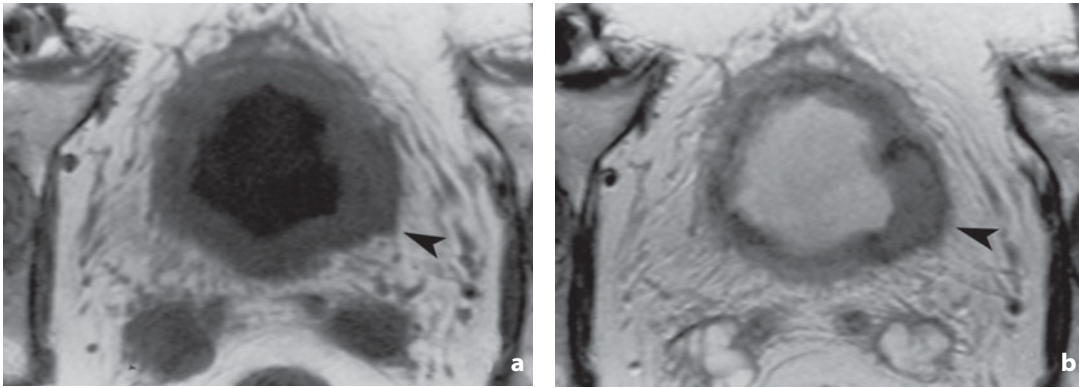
Magnetic resonance. Bladder cancer. a T1-weighted sequence shows concentric bladder wall thickening with irregularities of the left posterolateral profile (*arrowhead*). b The finding, which can be attributed to invasion of the adipose tissue (stage T3) is better visualized in the contrast-enhanced T1-weighted image
